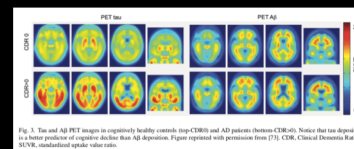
The use of PET imaging in cognitively healthy controls (top) and AD patients (bottom). Notice that tau deposition is a better predictor of cognitive decline than Aβ deposition. Figure reprinted with permission from [75]. CDR, Clinical Dementia Rating; SUVr, standardized uptake value ratio.
